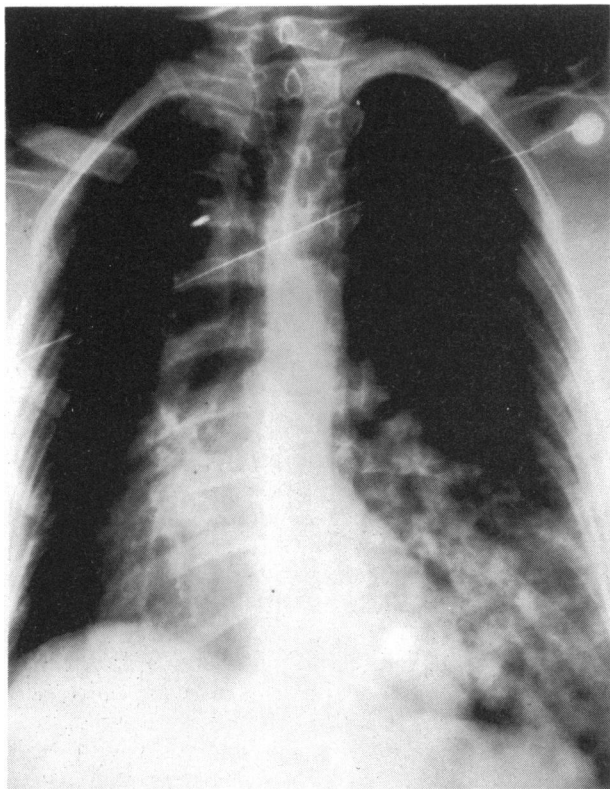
Admission X-Ray Film from Patient 1.
